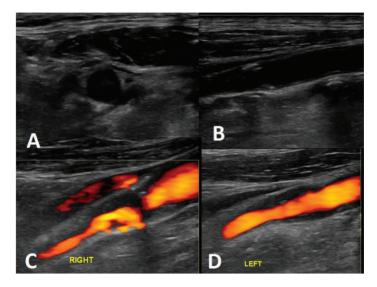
CDU on B-mode Doppler demonstrating irregular heterogenous plaque at ICA causing significant narrowing of the lumen as seen in transverse (A) and longitudinal plane (B). Power Doppler showing reduced flow in right ICA (C) and normal flow across left ICA (D).
